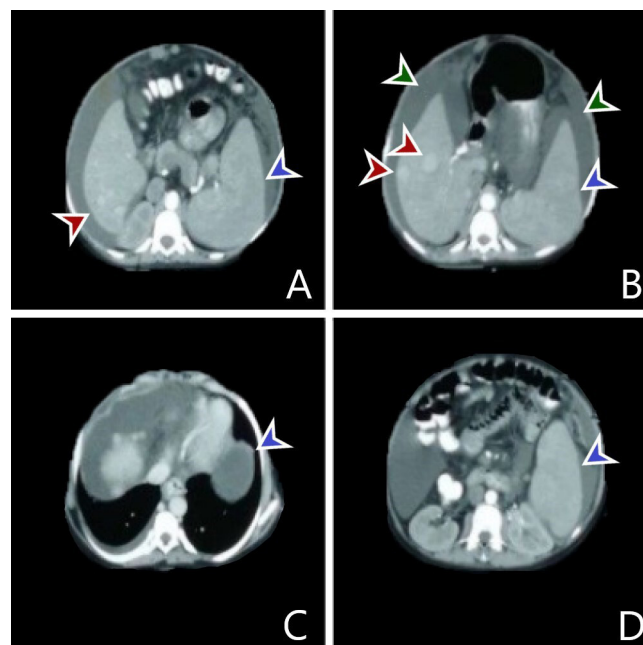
Contrast CT sections of the abdomen. Gross ascites (marked in green), multiple liver opacities (marked in red) and massive splenomegaly (marked in blue).
